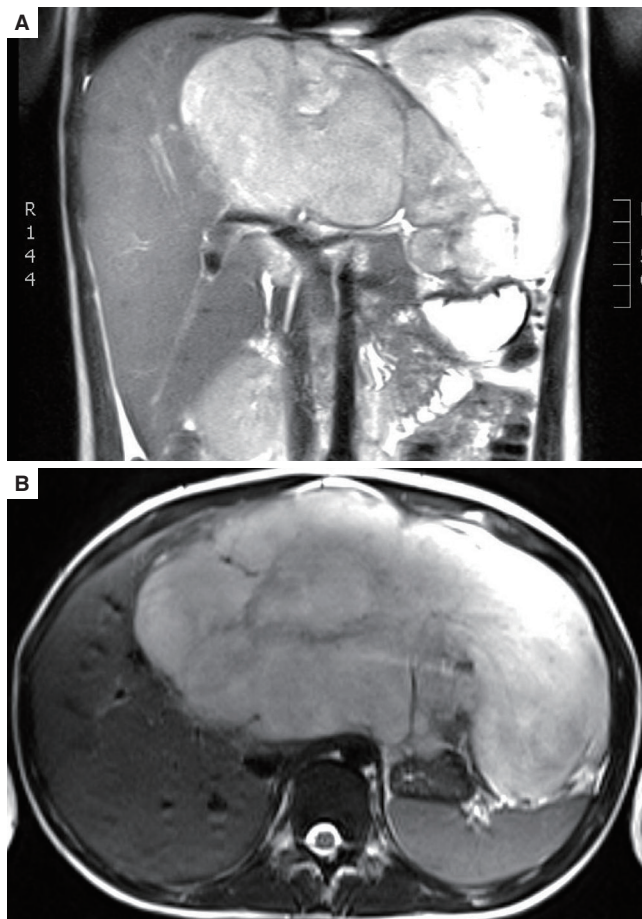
Abdominal magnetic resonance imaging (A: coronal; B: axial) revealed an 18.3 cm large heterogeneous enhancing mass with cystic components arising from the left hepatic lobe with associated mass effect
